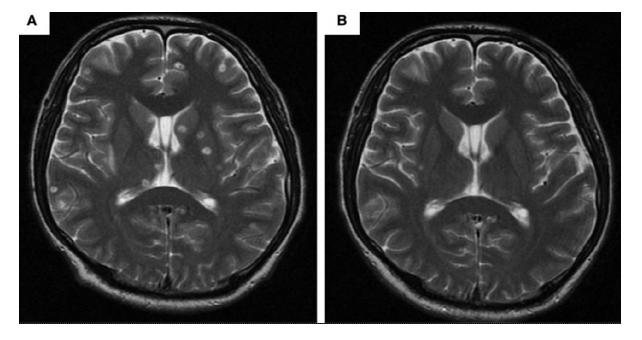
Brain MRI images were taken before (A) and after (B) treatment. Multiple cysts can be seen within the parenchyma (A) before albendazole (15mg for 28 days) cleared all the lesions (B) 9.
